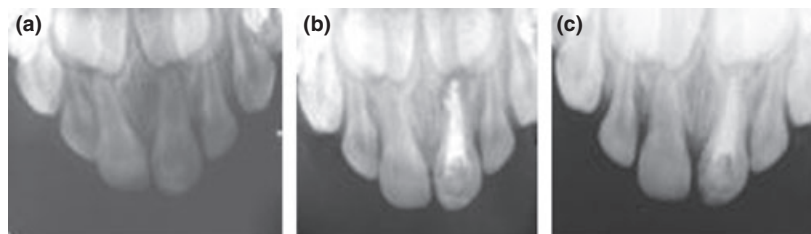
Radiographic success of zinc oxide and eugenol cement (ZOE) treatment at 18-month follow up. (a) Initial radiograph: tooth 61 with periapical radiolucent image. (b) Complete filling of the canal with ZOE. (c) After 18 months: absence of periapical radiolucent image.
